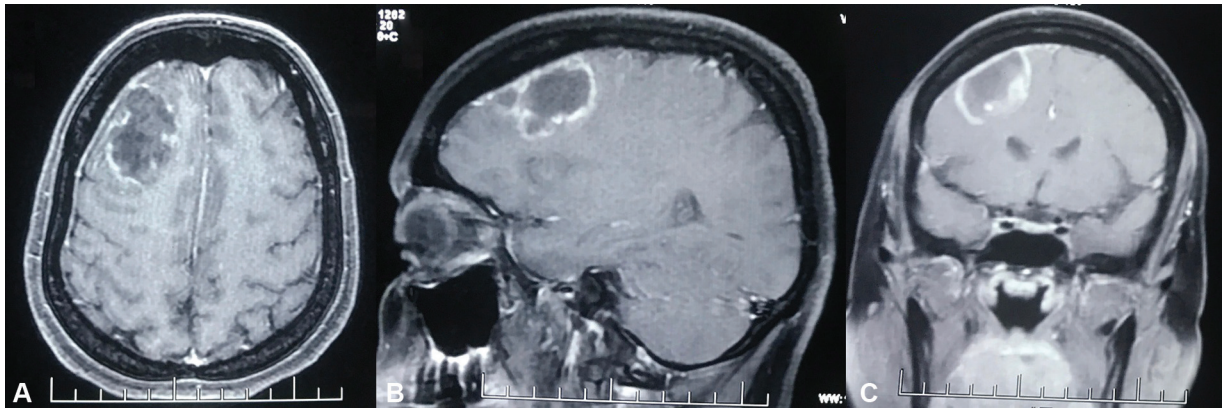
Axial (A), sagittal (B), and coronal (C) contrast magnetic resonance imaging brain showing peripheral irregular incomplete rim enhancing right frontal lobe lesion.
